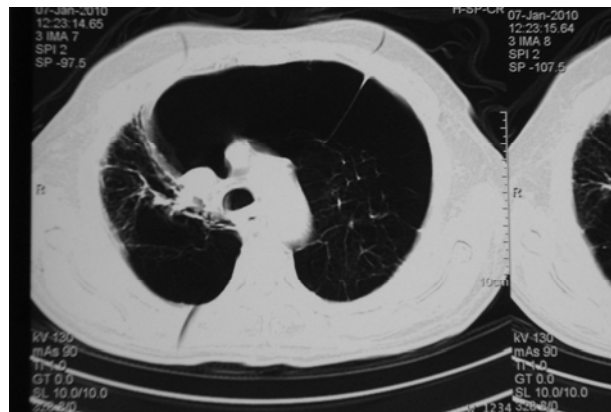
High resolution computed tomography of the chest revealed anterior herniation of a left pulmonary bulla from left to right side across midline causing volume loss and compression collapse of right upper lobe with resultant shifting of upper mediastinum slightly towards the right side.
